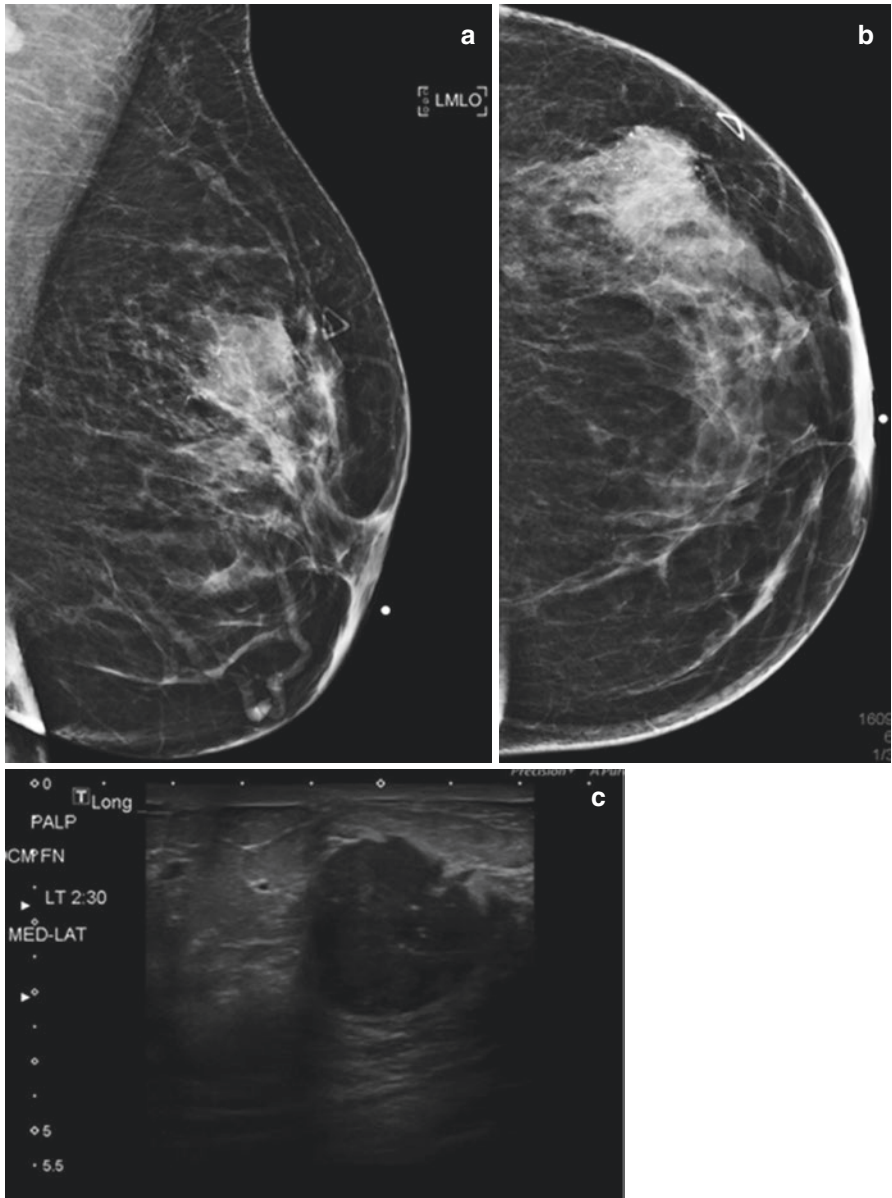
Mammogram. (a) Left MLO view. (b) Left CC view. (c) Targeted left breast ultrasound
